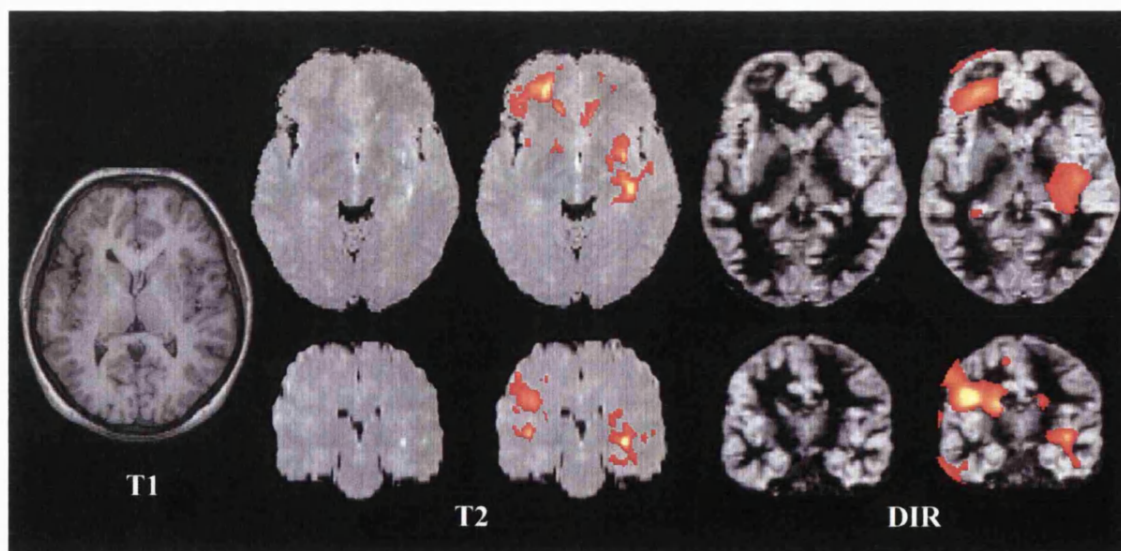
Patient with a left perisylvian gyral abnormality. Normalised axial (top) and coronal (bottom) T2-mapping (T2), and double inversion recovery (DIR) images; with superimposed regions of significant abnormality identified by SPM. The right perisylvian region / insula appeared normal on conventional MRI (T1). Note that right on the image is patient's right.
